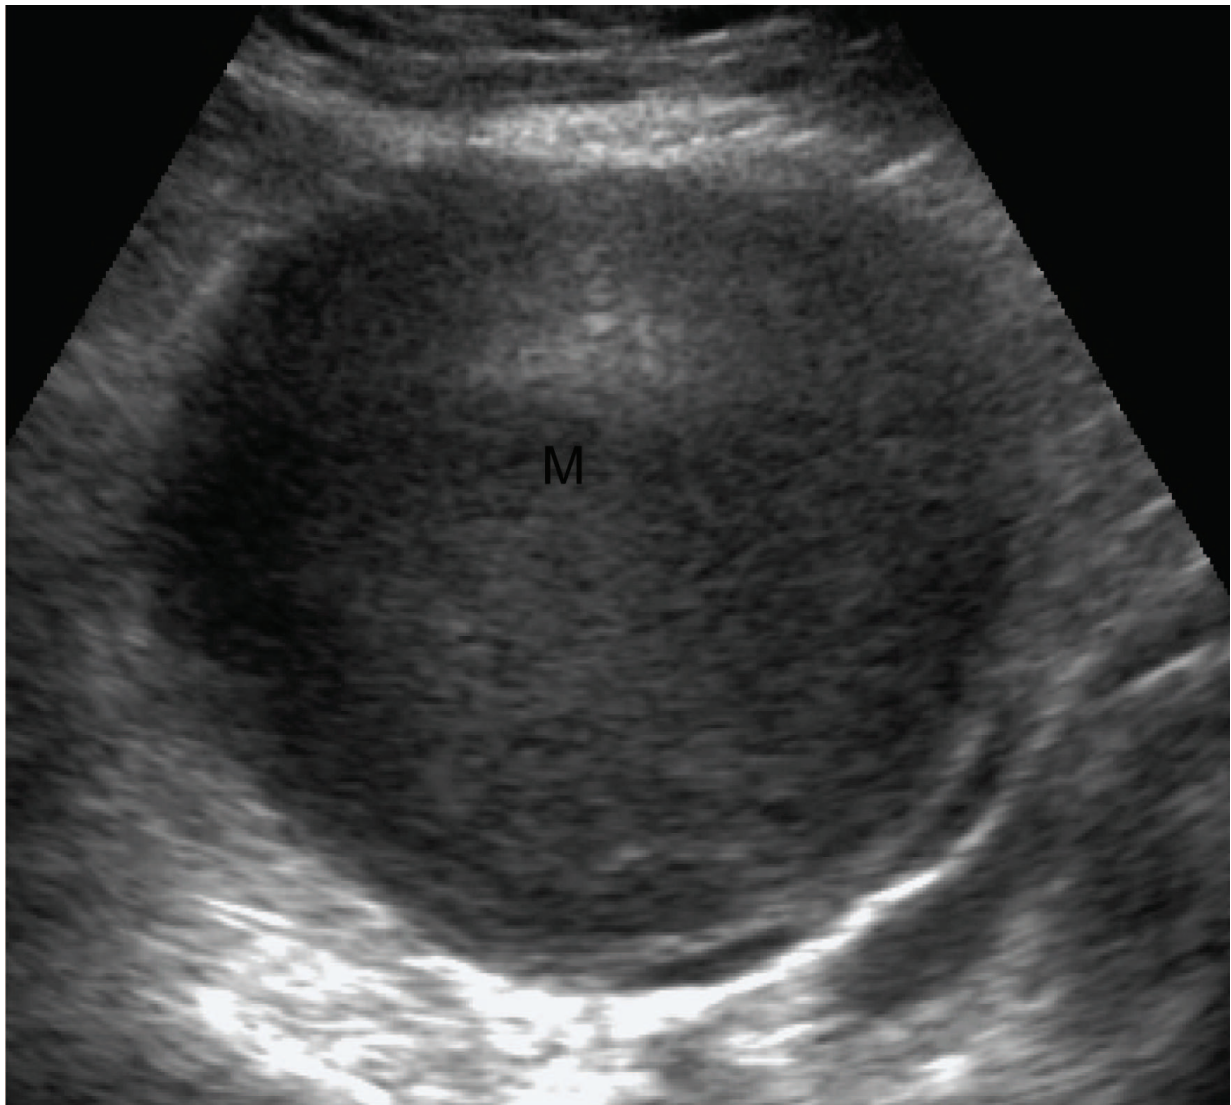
Grey-scale Transvaginal ultrasound of an endometrioma(M). Note the characteristic diffuse, low-level echoes of the endometrioma giving a solid appearance
